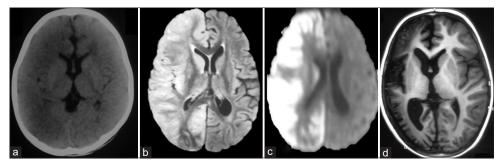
Infantile hemiplegia hemiconvulsion epilepsy syndrome (IHHE) (a) Noncontrast CT showing diffuse edema with loss of cortico-medullary junction differentiation of the right hemisphere, (b) FLAIR image showing right hemispheric cortical edema and caudate hyper-intensity with minimal midline shift anteriorly, (c) Right-hemispheric cortical diffusion restriction suggestive of cytotoxic edema, and (d) right-hemispheric cortical atrophy at follow-up
